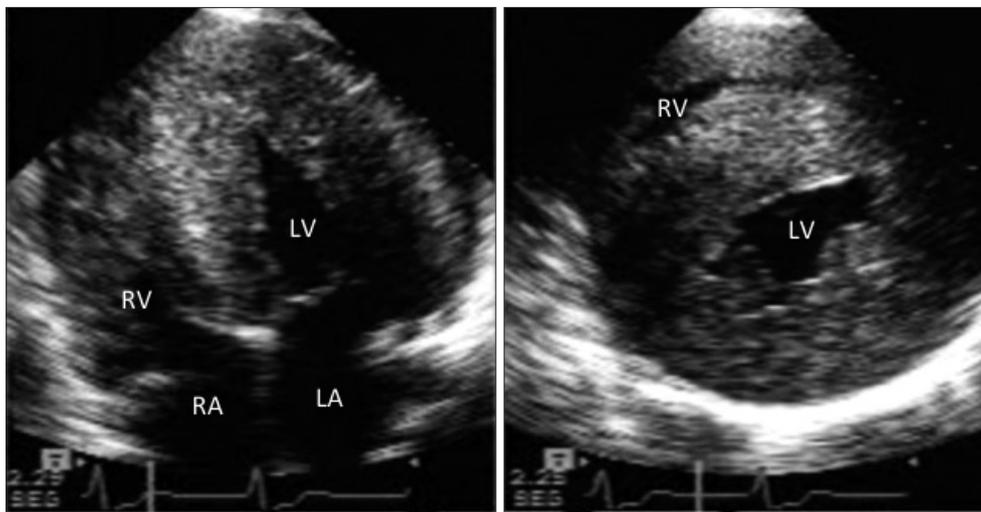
Two-dimensional transthoracic echocardiography in an apical 4 chambers plane and short axis view at the level of both ventricles, showing concentric hypertrophic cardiomyopathy. LA: left atrium, LV: left ventricle, RA: right atrium, RV: right ventricle.
